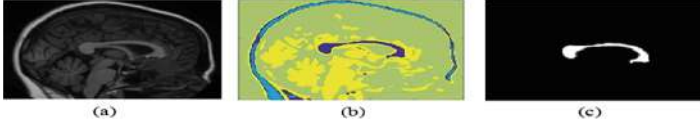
CC segmentation: (a) Input sagittal MRI. (b) Cluster Map. (c) Isolated CC.
